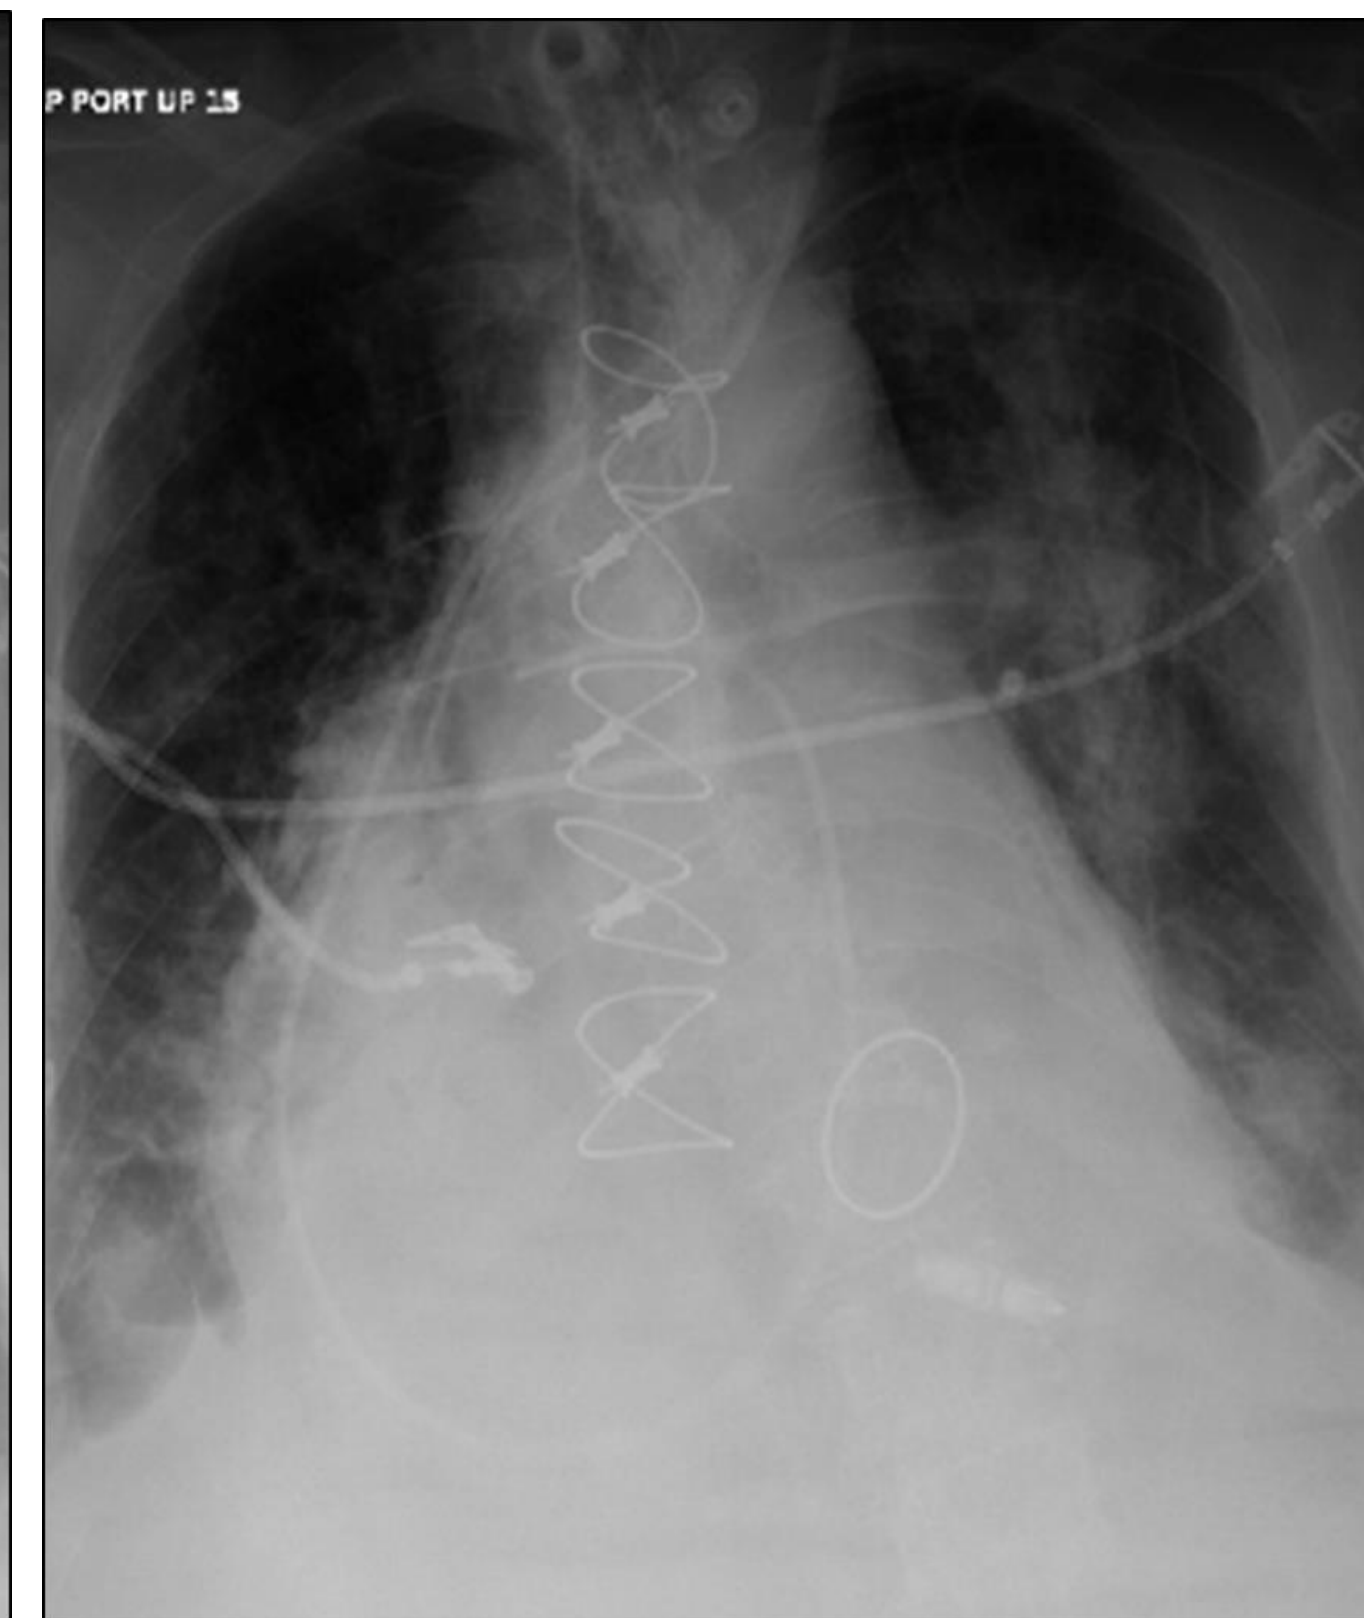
X-ray image showing the PAC in the RA with the tip pointing back toward the RA
